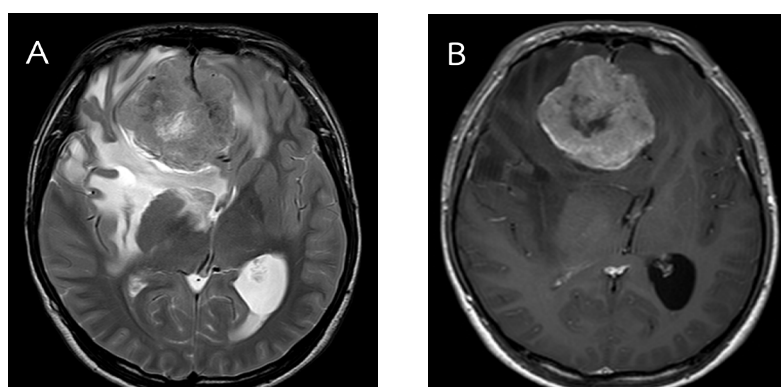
Axial T2- (A) and T1-weighted post-contrast (B) magnetic resonance images of a grade 2 meningioma showing heterogeneous enhancement of the tumor mass with central necrosis and peritumoral brain edema.
